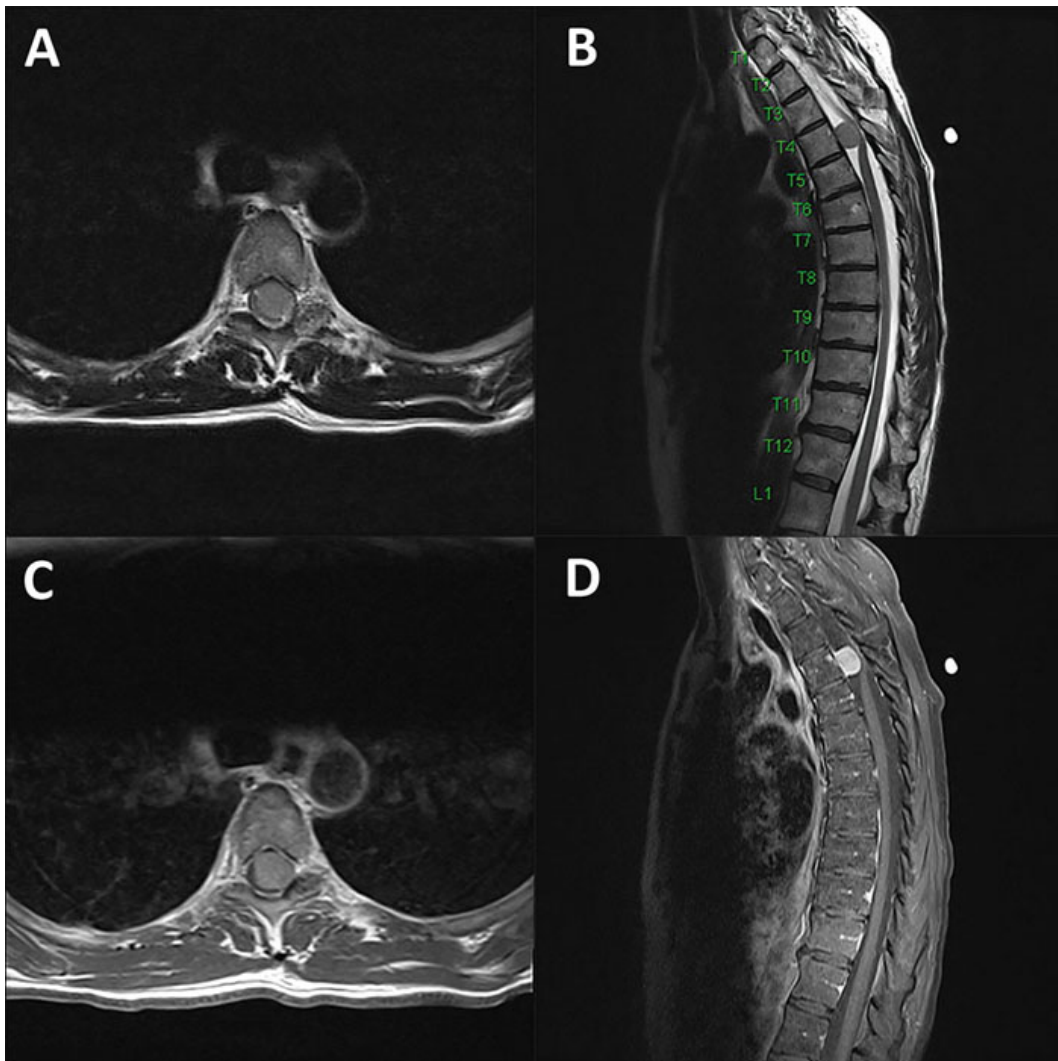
A and B shows T2 axial MRI and T2 sagittal MRI of the thoracic spine demonstrating an intradural extramedullary mass ventral to the spinal cord. C and D demonstrates T1 axial and T1 sagittal MRI with contrast shows a homogeneously enhancing mass with a thickened “dural tail”. The enhancing mass compresses and displaces the spinal cord dorsally and to the right.
